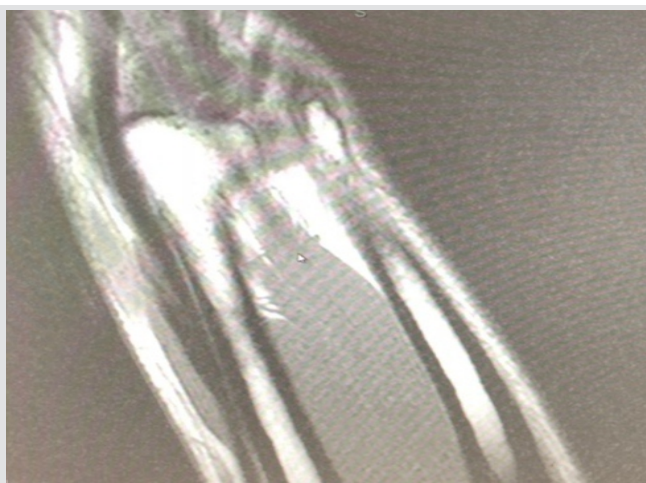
Sagittal view of the anterior left forearm mass demonstrating the muscle variant on magnetic resonance imaging (MRI) T1 without contrast 10 days after physical exam/MRI of the left upper extremity sagittal view.
